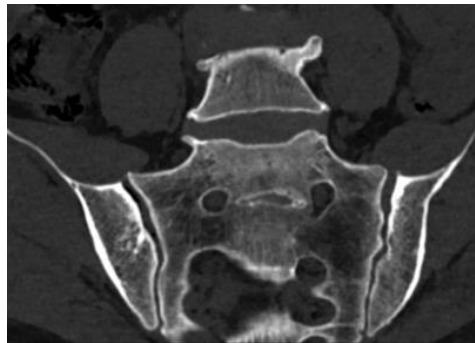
Sacroiliac joint CT demonstrated articular sclerosis, irregularity and narrowing of the sacroiliac joint spaces.
